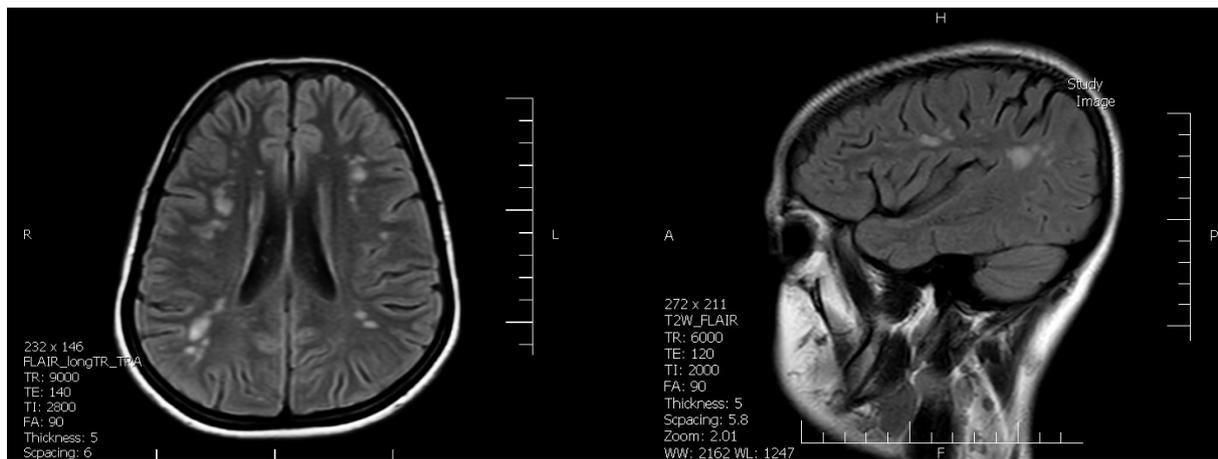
Brain MRI (FLAIR) showing bilateral subcortical white matter demyelinating lesions (Left: axial, Right: sagittal).
